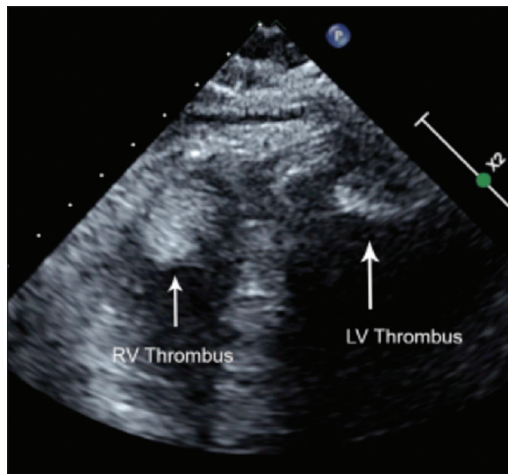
Apical four chamber view demonstrating bilateral apical ventricular thrombi. (LV- Left ventricle, RV-Right ventricle)
